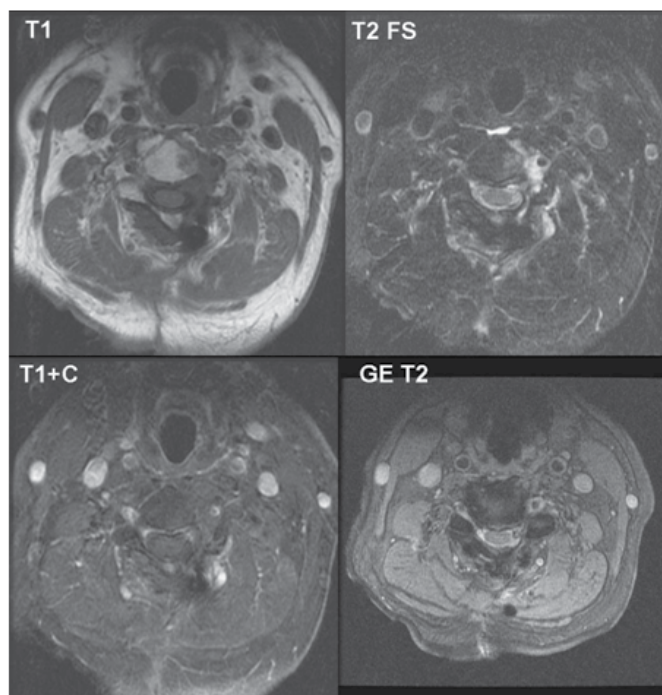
Postoperative C-spine MRI (axial view)The spinal cord was free from the compression, however, residual tumor was present.
